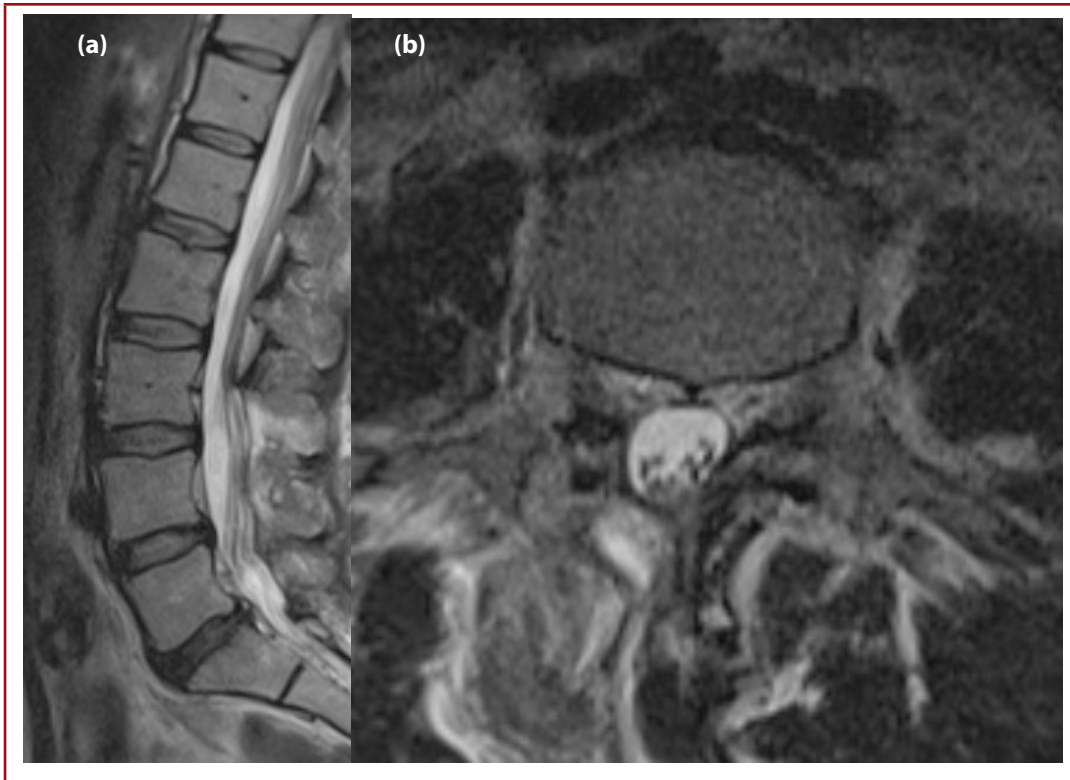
a,b. Postoperative magnetic resonance imaging sagittal image(left) and axial image(right)
